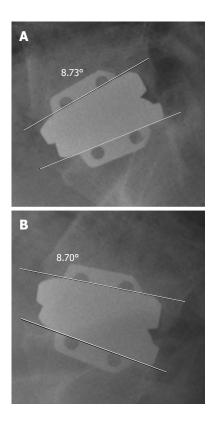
Two years after the operation, radiograph (Above: Extension; Beow: Flexion) shows range of motion of the implant was almost 0°.
